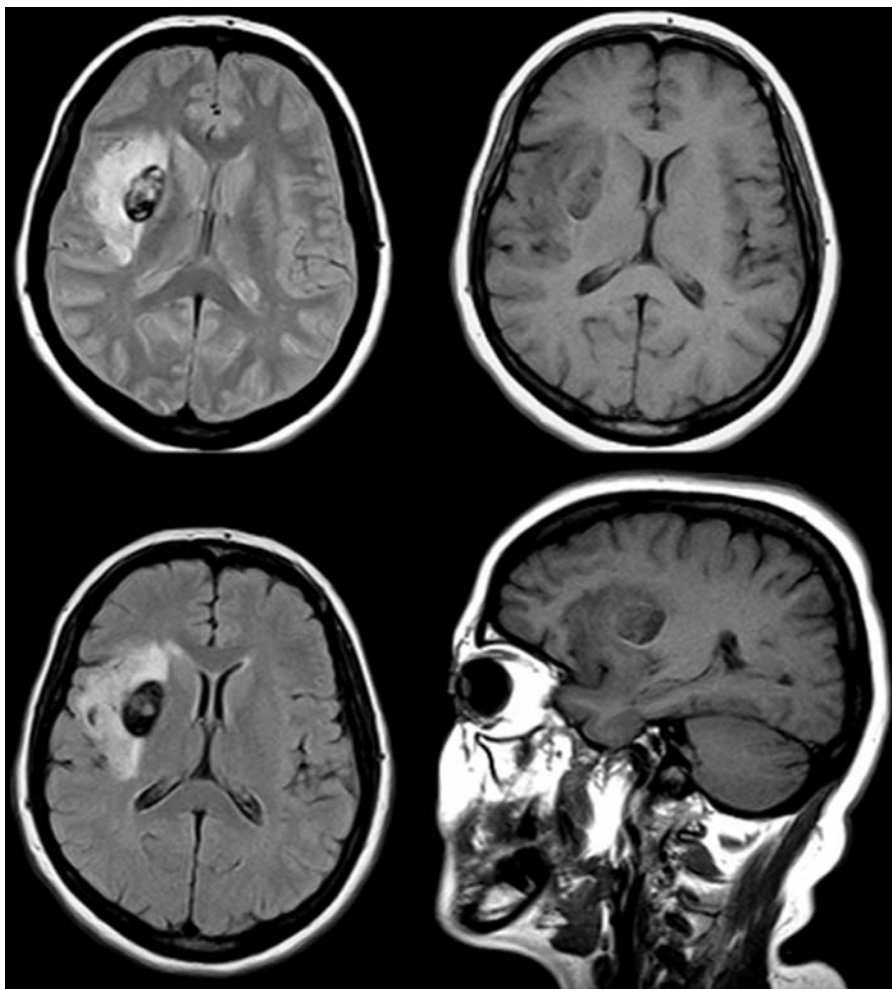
DP, T1 and FLAIR axial images at the same level, showing a dishomogeneous ovoid hypointense lesion (due to the presence of blood degradation products), characterized by marked lateral edema
